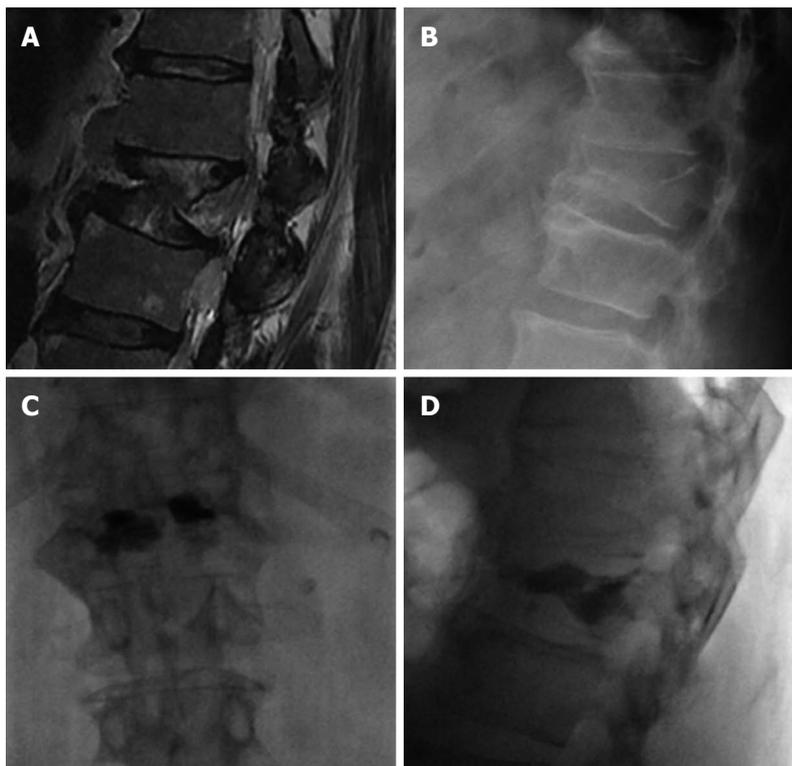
Sagittal T2 magnetic resonance weighted image (A) and lateral X-ray film (B) showing a severe collapse of L1, AP (C) and lateral (D) view after vessel-plasty.
